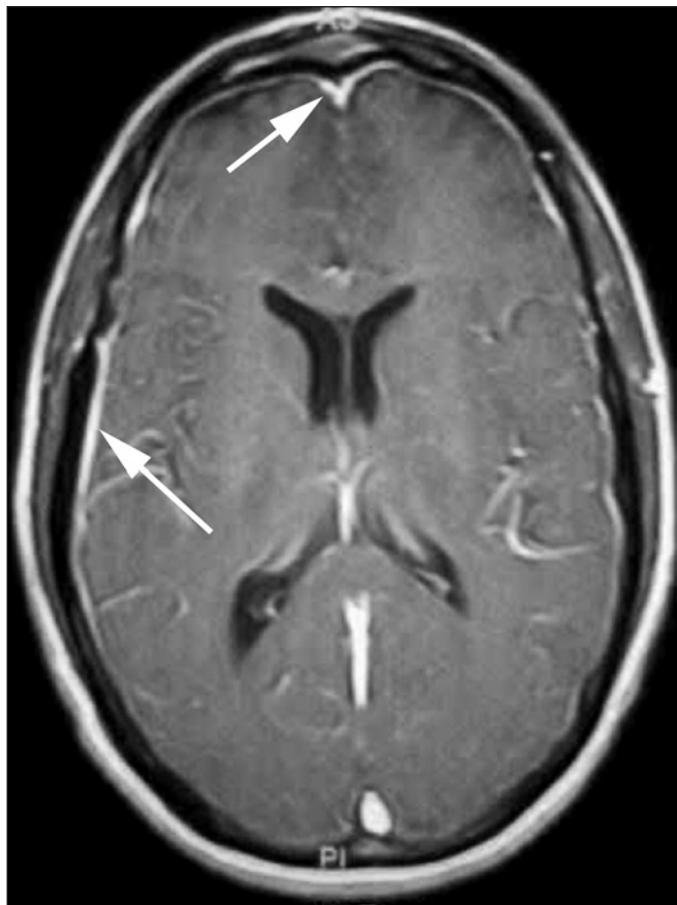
Brain magnetic resonance imaging in a patient with neurosyphilis and vitreitis: axial T-1 weighted image after gadolinium injection showing meningeal enhancement (arrows)
